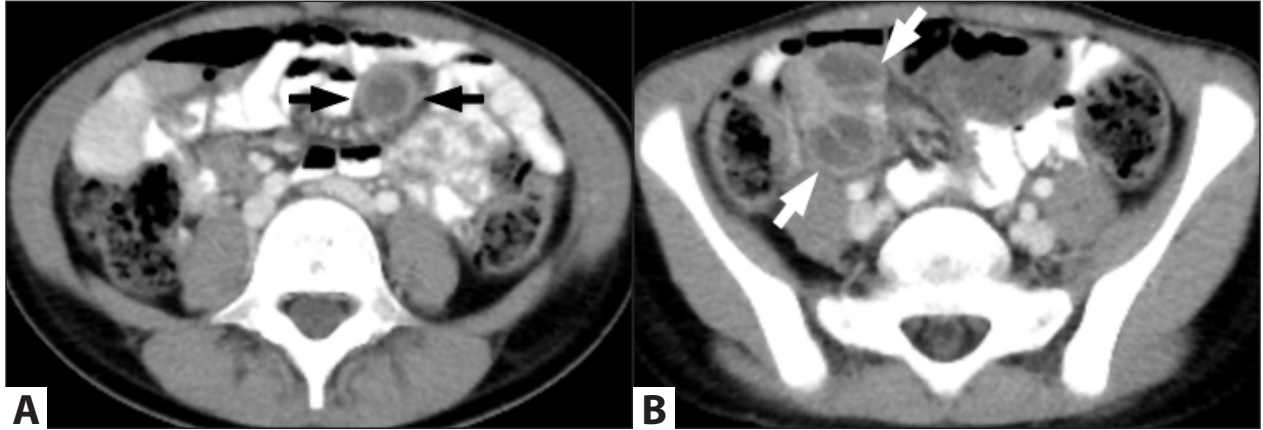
A. On an axial abdominal CT slice passing through the midline of the abdomen; a 17 mm lymph node with a hypodense, necrotic center is observed in the mesenteric region (arrows). B. Axial abdominal CT slice at the level of the pelvic inlet; in the right paracolic region, there are conglomerate necrotic lymphadenopathies extending into the pelvis, with contrast-enhancing walls and a hypodense center, approximately 25 mm in diameter (arrows).
